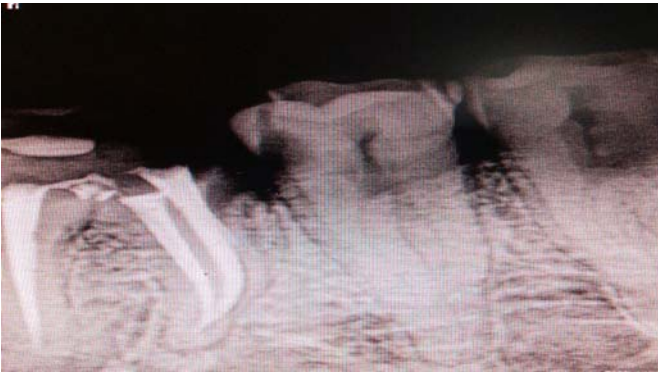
Pre-operative radiographic picture showing three root canals
